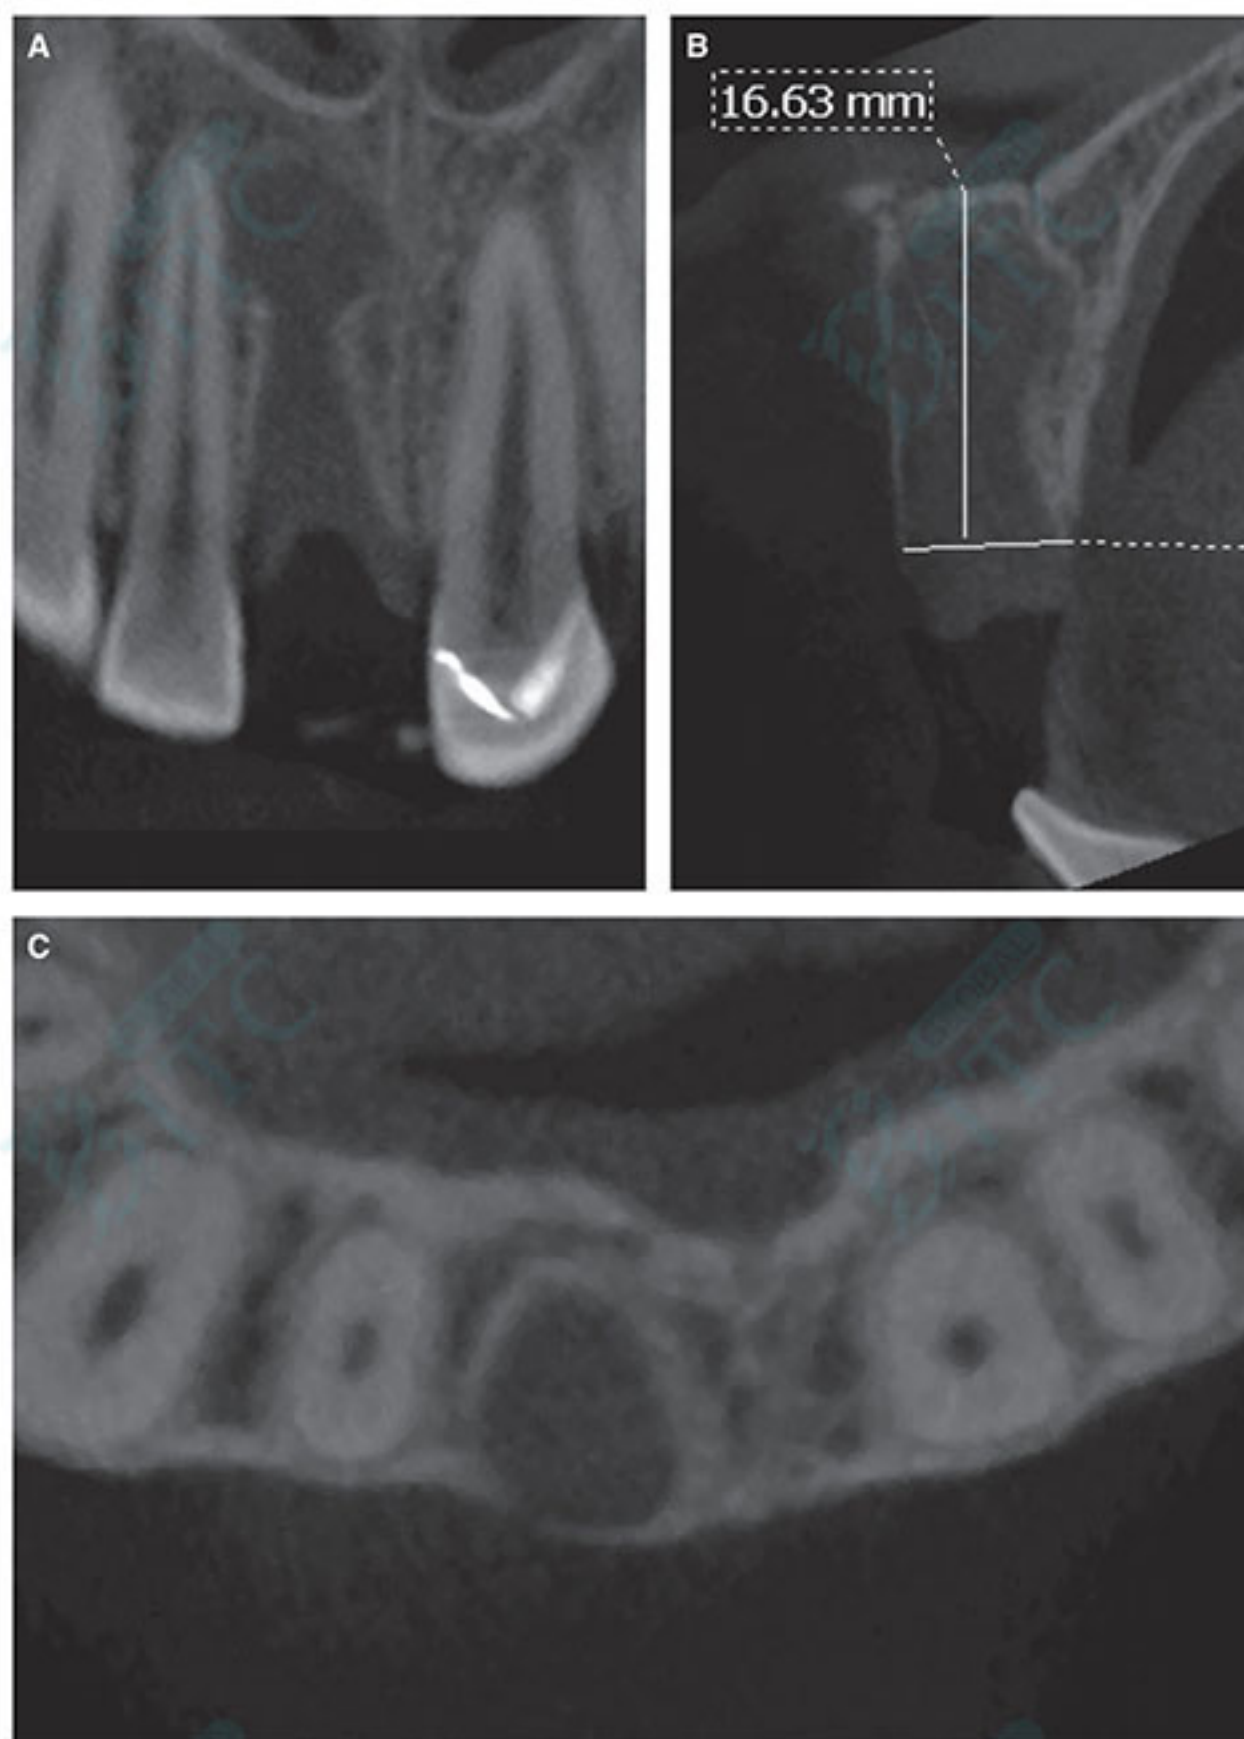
(A) CBCT of an extraction sockets, roughly 4 weeks post extraction. A mid-size periapical bone lesion is apparent. (B) The oro-facial cut clearly shows a huge extension of this lesion towards the floor of the nose. Considering the distance of 16 mm to the nasal floor, the achievement of a sufficient primary stability is not feasible with type I & II placement. Thus, a prolonged healing period of 16 weeks was chosen prior to implant placement (type III). (C) The horizontal cut shows excellent crest width 3 mm apical to the CEJ (approximately 8 mm). Thus, implant placement will pose no problem with a type III protocol.
